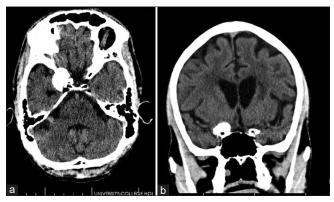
Axial (a) and coronal reformatted (b) computed tomography angiography showing aneurysmal dilatation of the right internal carotid artery. Background cerebral atrophy, as evidenced by prominent sulci and Sylvian fissures, is also noted
